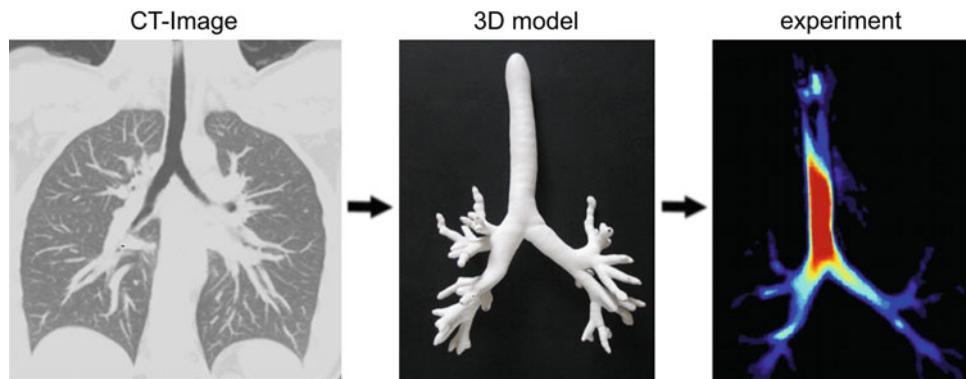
Rapid prototyping can be used in medical research for creating 3D models of living organs. In this work, a CT image data set of the bronchial tree was processed for rapid prototyping. A 3D model of the human trachea and bronchial tree was produced. The model was
